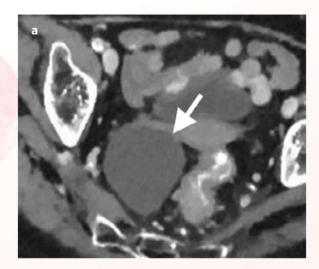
a. Transvaginal US image in a post-menopausal woman showing a 3cm simple cyst (between callipers) with thin walls and no internal structure. Ovary (O). b. CT scan image showing an incidental 3.5cm cyst (arrow) in a post-menopausal woman that had not changed from a CT scan taken 5 years earlier.
